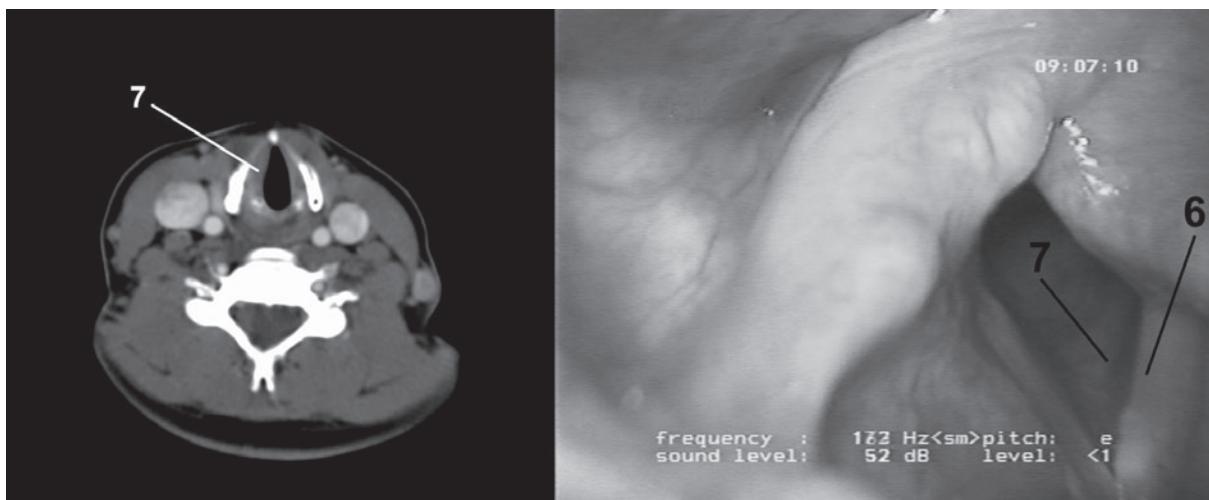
Widening of the laryngeal pouch (4) and thickening of the vocal fold (6) in CT and in laryngovideostroboscopy.
